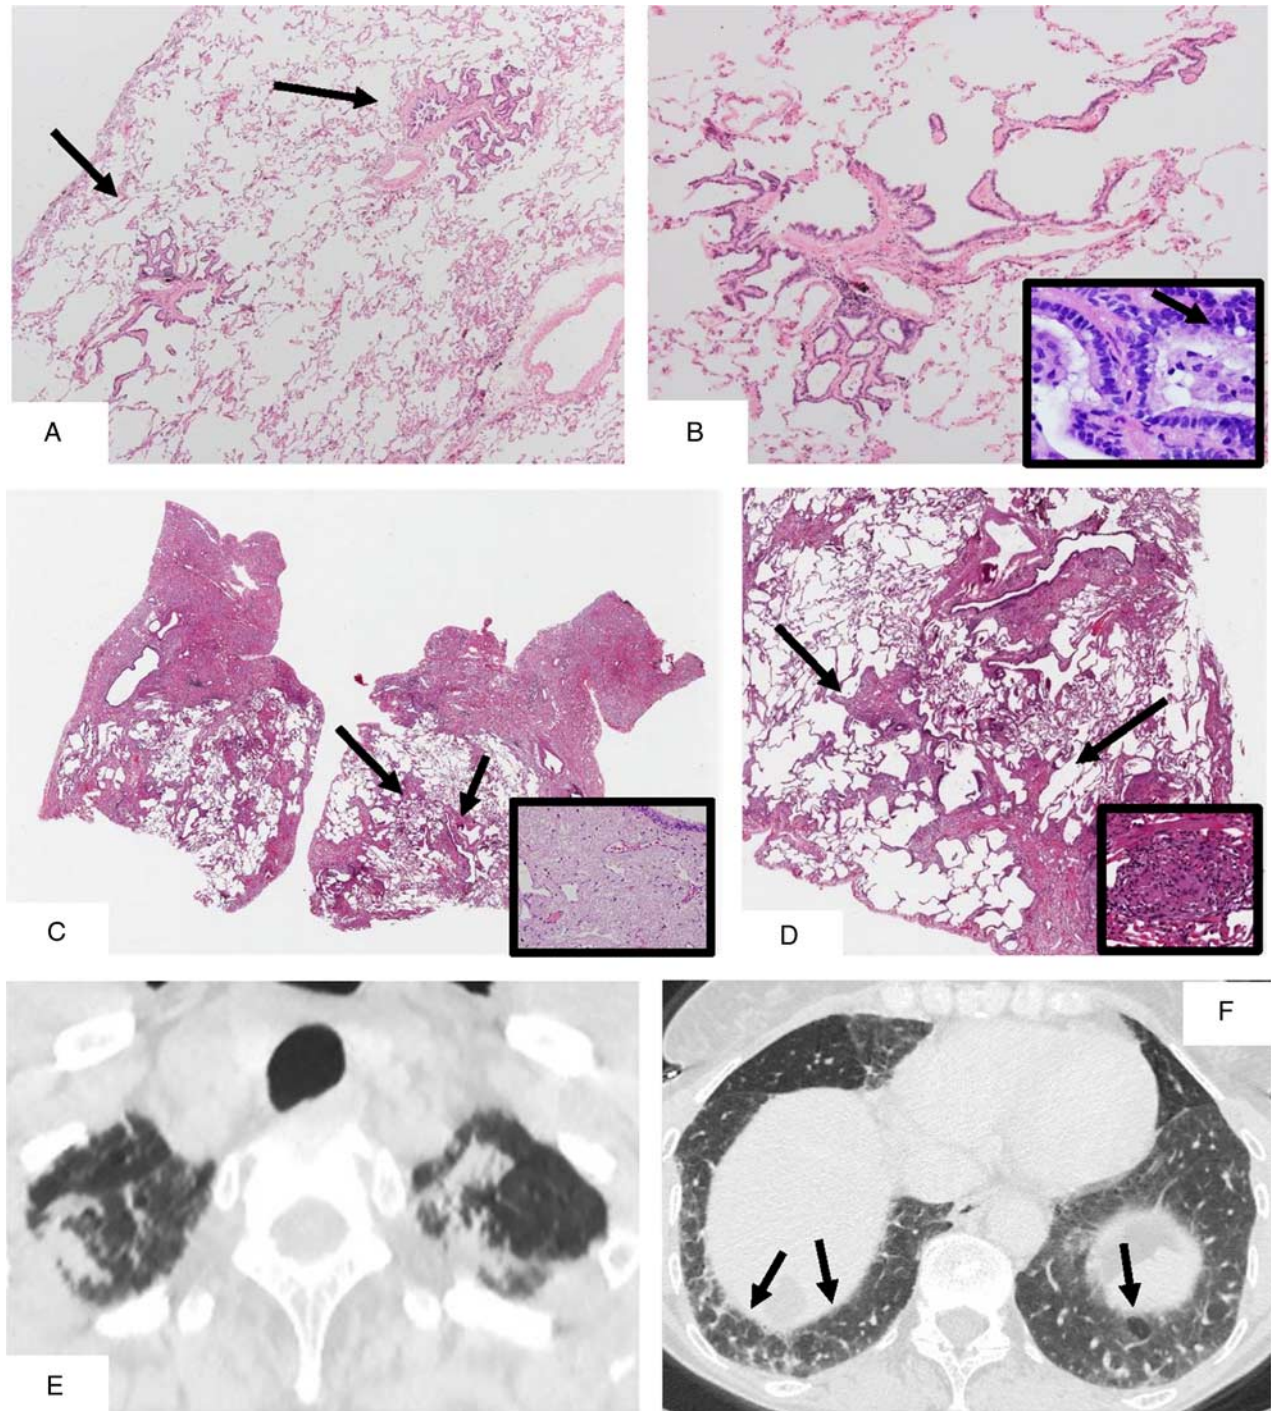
Airway-centered fibrosis: peribronchiolar metaplasia 1LD. A, The primary finding in this biopsy is that of bronchiolar fibrosis consisting of multiple small nodules (arrows). B, Peribronchiolar metaplasia is made up of bronchiolar wall fibrotic thickening with extension of the fibrosis into the adjacent alveolar walls causing mild thickening. The surrounding alveolar parenchyma is relatively normal. The inset shows bronchiolar epithelium with ciliated (arrow) and nonciliated columnar and cuboidal epithelial cells. Pleuroparenchymal fibroelastosis. (PPFE) C, This upper lobe biopsy shows extensive subpleural fibroelastotic fibrosis extending into the underlying lung parenchyma. The underlying lung parenchyma shows a bronchiolocentric cellular and fibrosing process (arrows). High power of the fibroelastotic connective tissue shows numerous elastic fibers (inset). D, This intermediate magnification shows the bronchiolocentric cellular inflammation and fibrosis (arrows). Poorly formed granulomas were present on high power (inset). E, The HRCT of the upper lobes shows bilateral dense parenchymal opacities corresponding to the subpleural fibroelastotic scars of PPFE. F, This expiratory HRCT shows patchy ground-glass opacities with multilobular air trapping (arrows).
